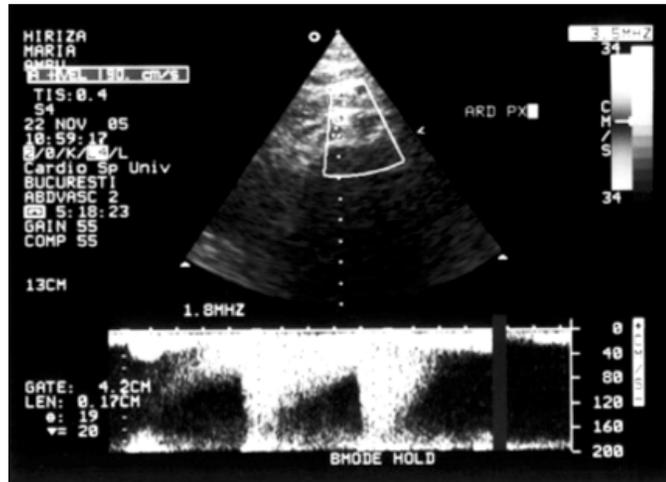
Doppler right renal artery stenosis in the proximal segment, at the origin
